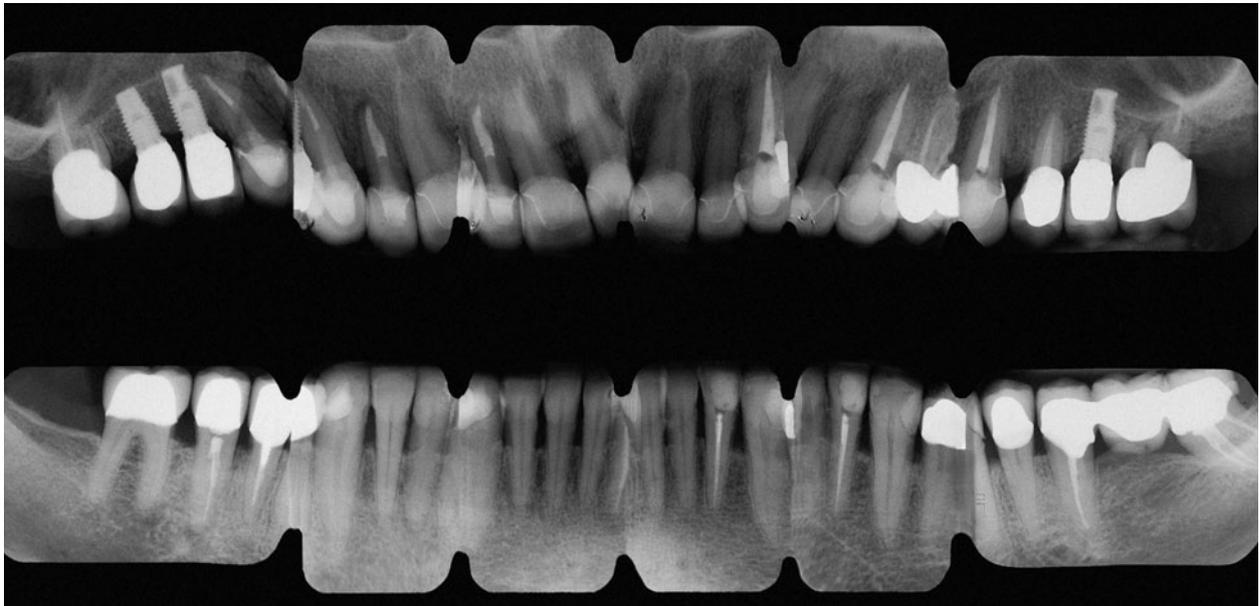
Postoperative radiograph exhibits a good level of precision, appreciable for the different types of metal-free restorations used. The radio-transparency of glass-ceramic and of lithium-disilicate is evident in comparison with the radio-opacity of zirconia structures.
